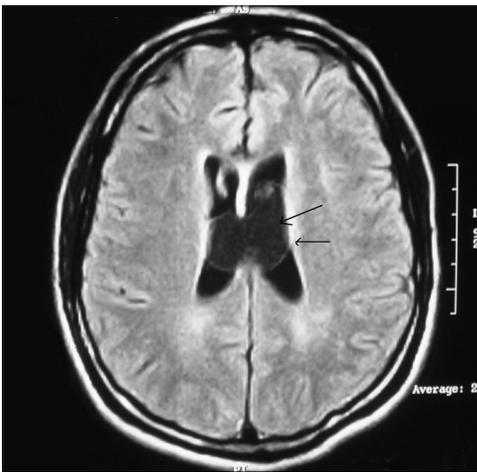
MRI axial view showing the hypointense cyst in the third ventricle extending into lateral ventricles. The eccentric scolex is clearly visible (arrow)
